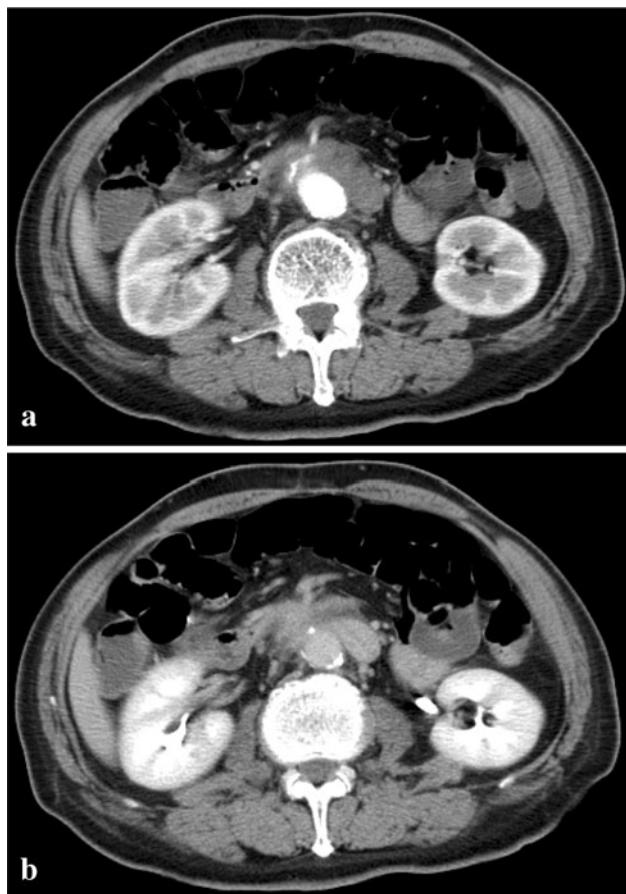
Contrast-enhanced abdominal CT scans on admission. a Early arterial phase. b Late perfusion phase. Contrast-enhanced abdominal CT scanning revealed a para-aortic area of weak late-phase contrast uptake at the level of the graft anastomosis, with an indistinct border with the duodenum, raising the suspicion of a fistula between the abdominal aorta and the duodenum associated with infection
